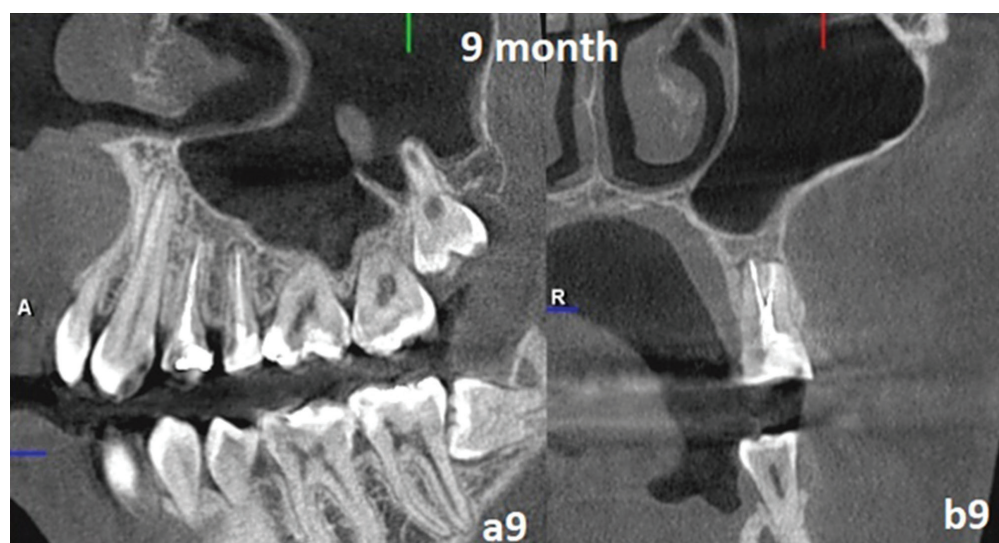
CBCT evaluation of teeth 24 and 25 nine months after surgical treatment: (a9) coronal section; (b9) sagittal section.
